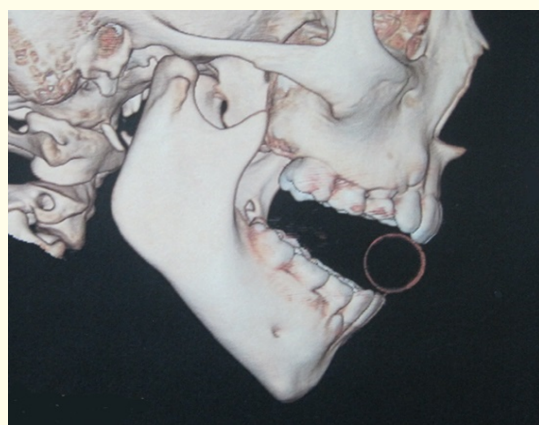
Computed tomography with 3D reconstruction showing the right condyle after the period of bone healing.
